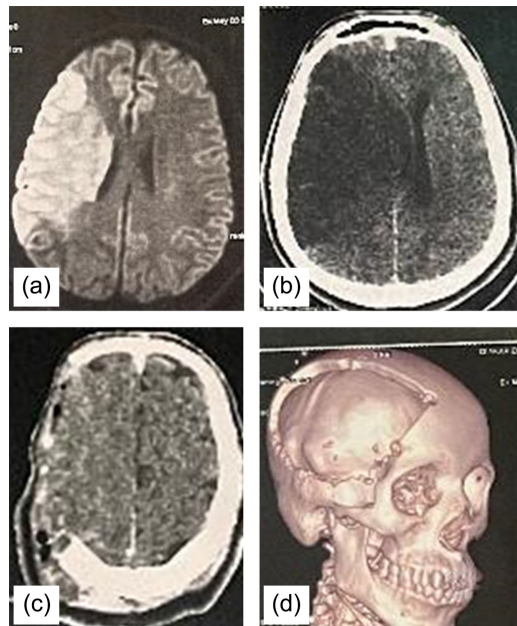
Early MRI (a) at stroke onset in patient 9 and preoperative CT scan 72 h later after worsening. Postoperative CT scan in axial (c) and 3D (d) views.
